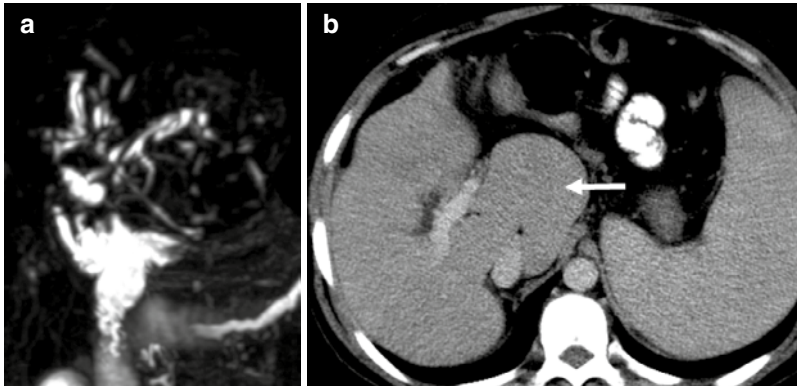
Primary sclerosing cholangitis (PSC). MRCP (a) shows a beaded appearance of the biliary tree. Contrast-enhanced CT (b) through the upper abdomen
